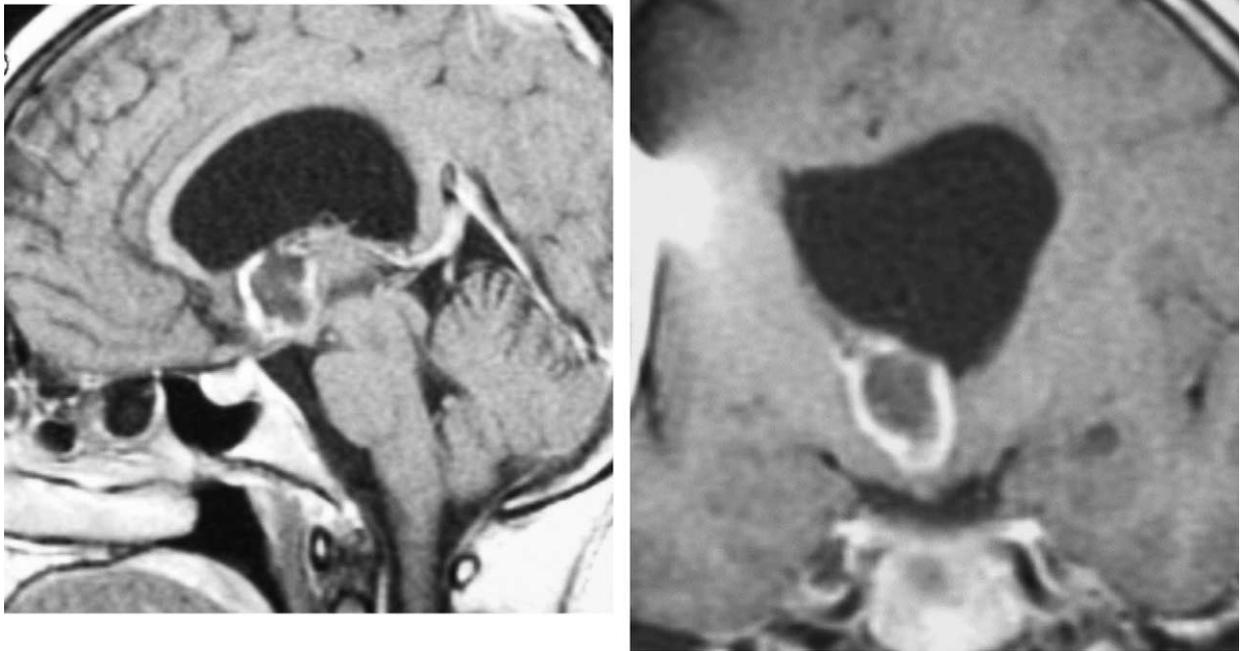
Preoperative T1-weighted magnetic resonance imaging after gadolinium-DTPA administration. Left: sagittal section showing a solitary anterior third ventricle mass with ring enhancement. Right: coronal section in the same area showing a ring enhanced mass surrounded by intact hypothalamus nuclei.
